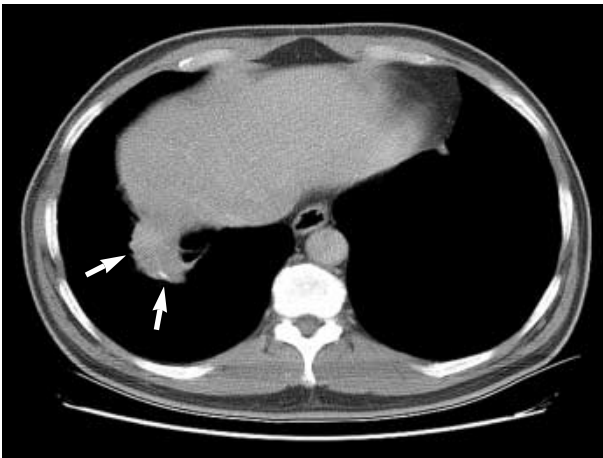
CT reveals a mass of about 4.2 cm in largest diameter in medial basal segment of right lower lobe (arrows). Converging of vessels and bronchi near the mass gives the appearance of a comet-tail.
